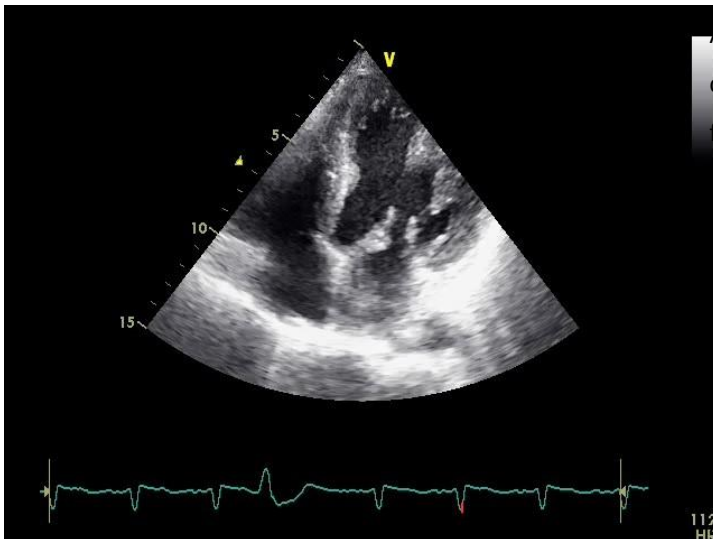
Transthoracic echocardiography (apical four chamber view) showing mitral leaflet vegetations.
